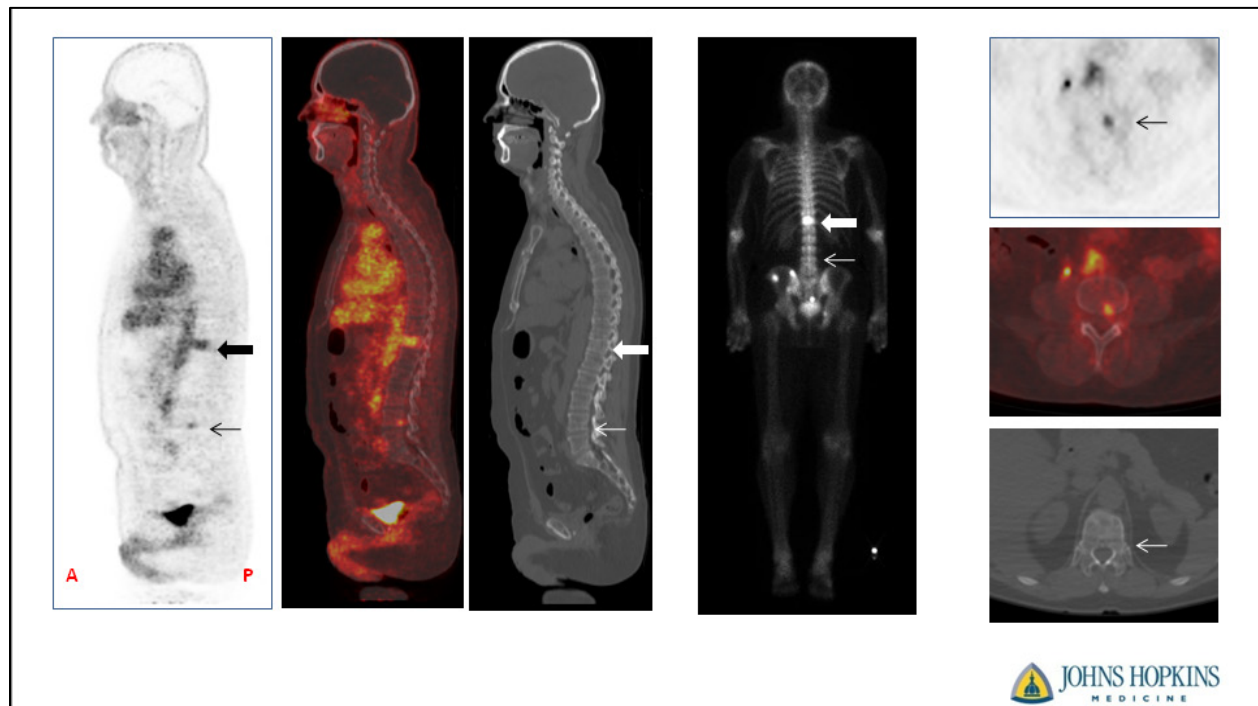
Example of PET/CT scanning using the PSMA-targeted imaging radiotracer, [^{18}F] DCFBC, compared to a standard conventional bone scan (CT) in the same patient.
